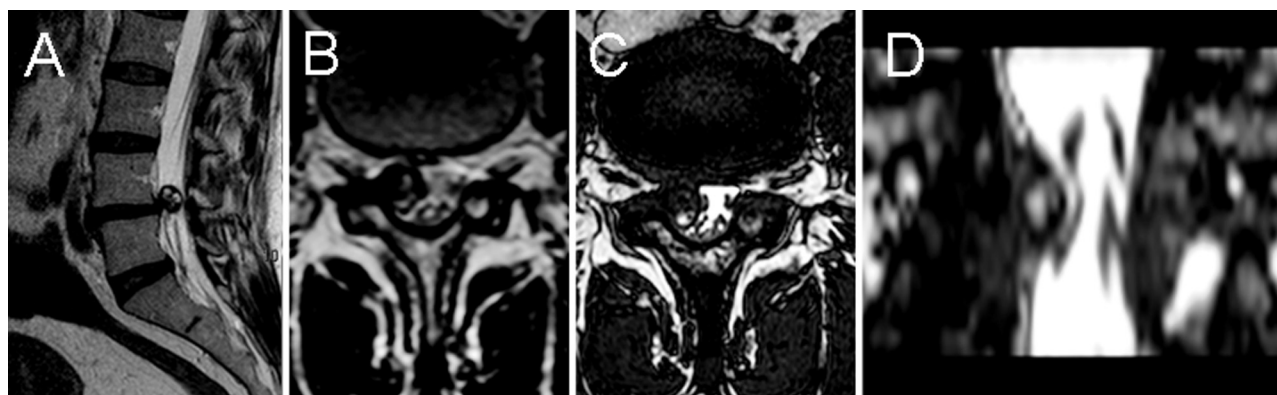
Sagittal (A) and axial (B) T2-weighted magnetic resonance images showing a hypo-hysointense cystic round-shaped lesion adjacent to the L4-L5 right facet joint. Axial (C) and coronal (D) 3D-FIESTA acquisitions, confirming the extradural origin of the lesion and the severe compression of the right L5 nerve root and of the dural sac.
